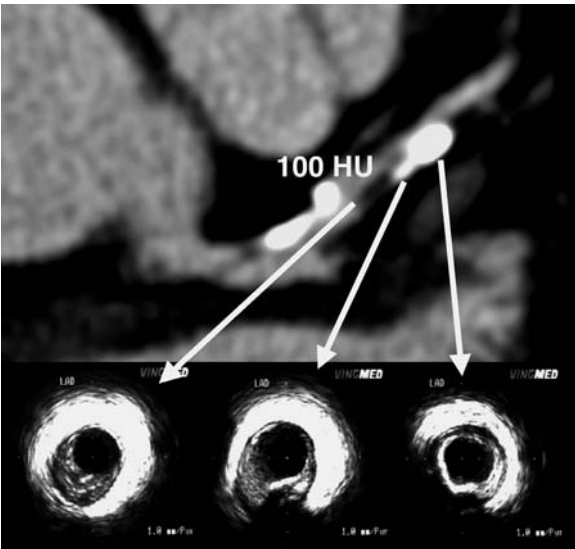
The positive predictive value of diffuse coronary calcifications is 56%. Figure shows different types of coronary artery wall lesions in comparison with intravascular ultrasound. All lesions cause stenosis of the vessel. Diffuse calcification (*right*), mixed lesion with calcified components (*middle*), and non-calcified lesion component with soft tissue attenuation of 100 HU (*left*)
